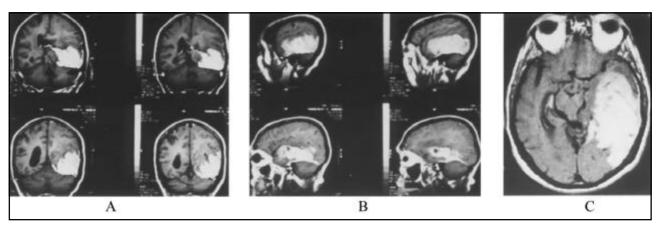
MRI in coronal (A), sagittal (B) and transversal (C) view obtained with contrast agent showed an enhancing tumor in left temporooccipital lobe and a transtentorial herniation.
